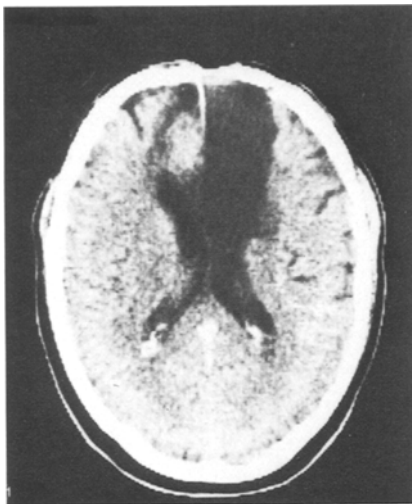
Case 3. CT scan some 3 years after lesion from a "Slaughterer's gun" in right frontal region. Note the cortical atrophy in both hemispheres frontally
